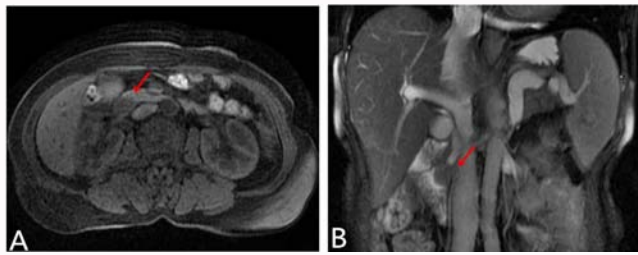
Abdominal MRI showed the tumor size was 22 mm x 19 mm (A) and the location was in duodenal papilla (B).
